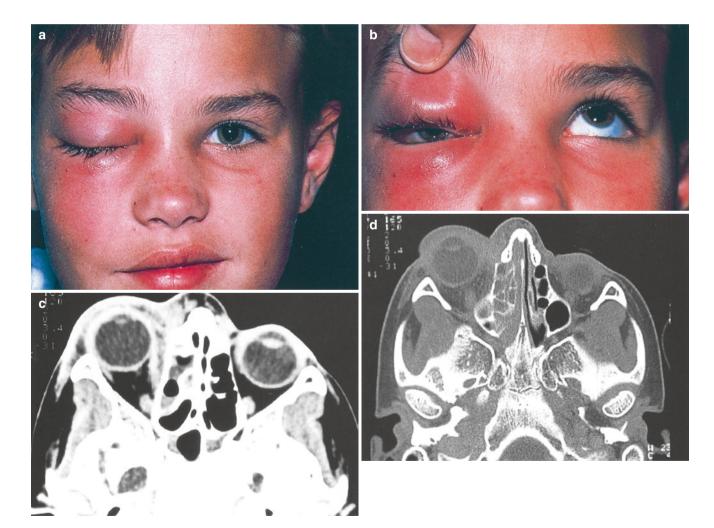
Orbital cellulitis. (a) External photograph shows edema and erythema of the right periocular region. (b) This patient's attempted upgaze with limitation of motility. (c) CT scan shows the soft tissue
